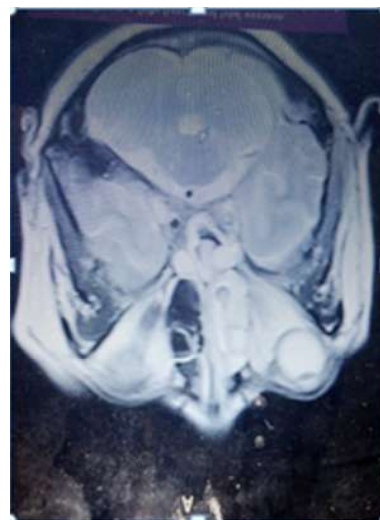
MRI brain showing absence of flow void in left ICA and mucosal thickening in left nose and paranasal sinus.
